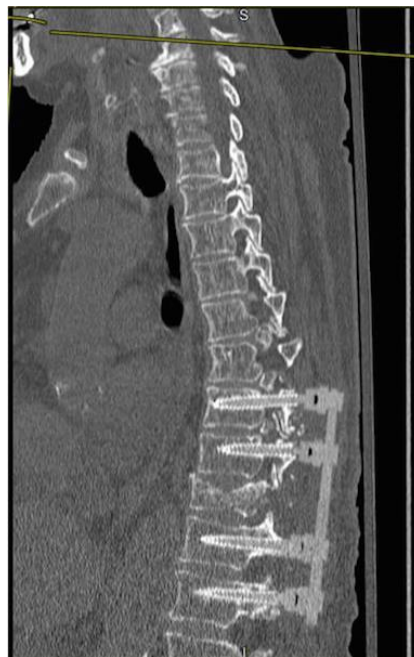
Post-operative CT scan demonstrating T8-12 fusion. (There is limited artefact present. The patient passed away in December 2020, 6 months following her surgery.)
